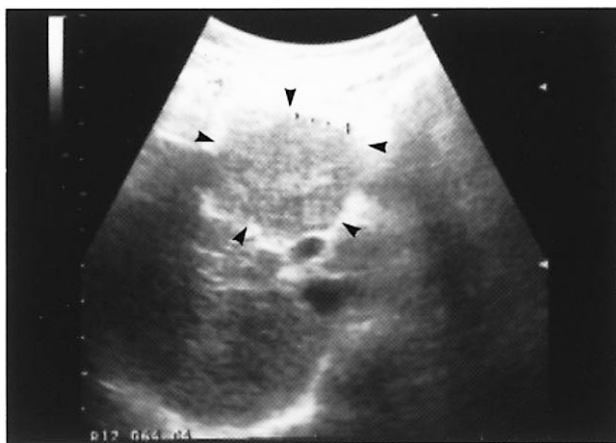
Ultrasound sonography shows the enlarged medial segment of the liver (arrowheads).
